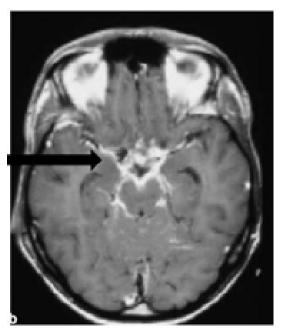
MRI brain showing basal meningeal enhancement on T1 post contrast image
